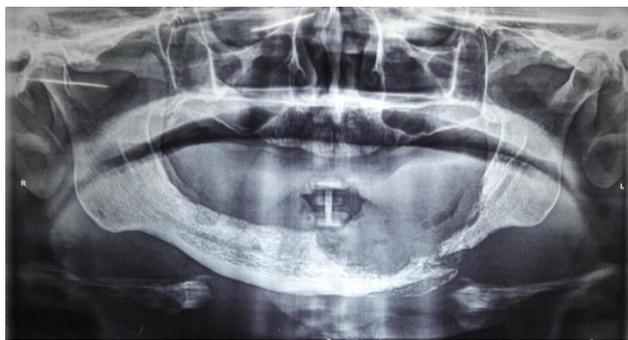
Orthopantomograph showing an osteolytic lesion in the left posterior mandible
